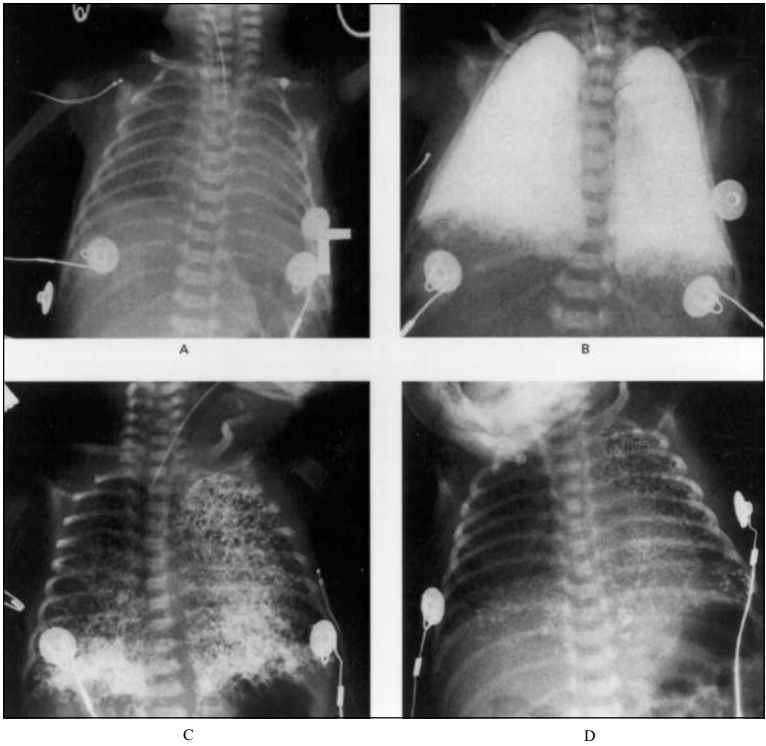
Chest x-rays of an infant before (A), during (B), 48 hours after (C), and 3 weeks after (D), treatment with PLV.
